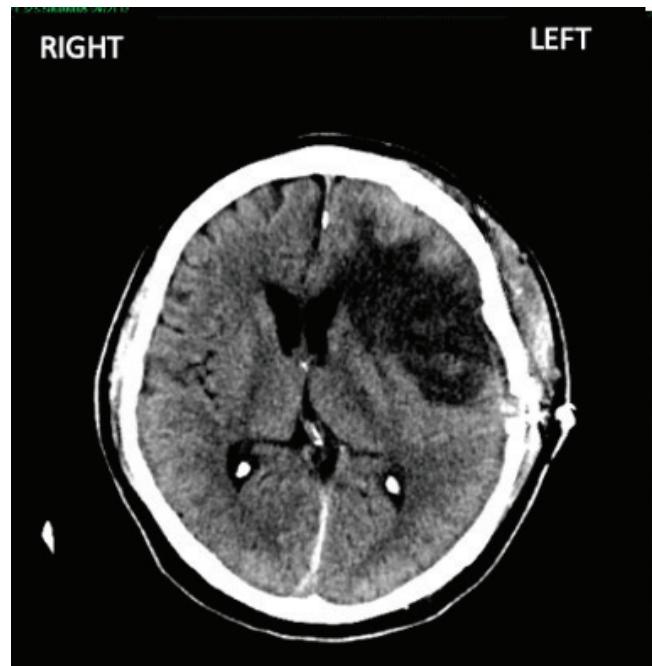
Coronal view of CT brain showing left fronto-temporo-parietal collection with mass effect and cerebral oedema.
